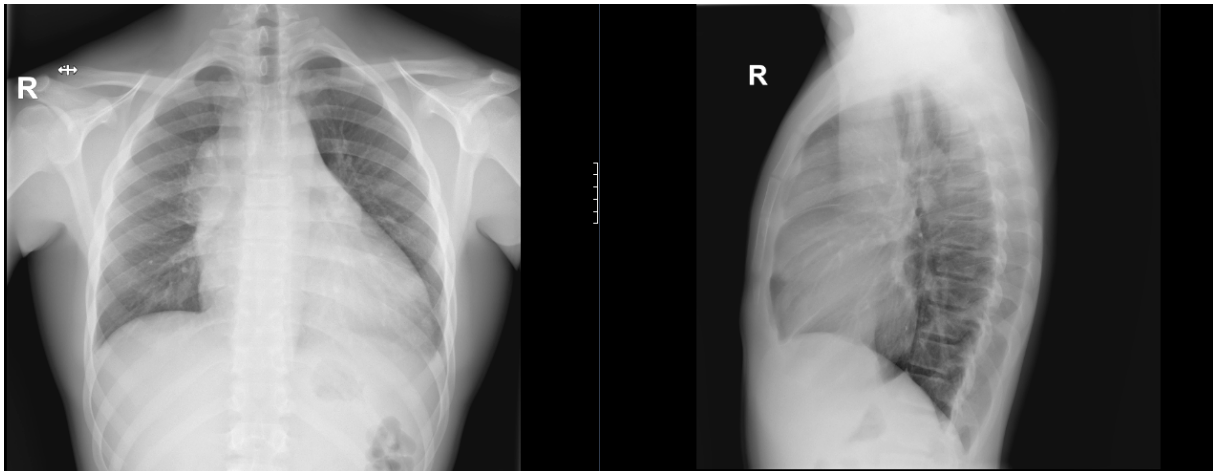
The posteroanterior and latero-lateral chest X-ray
